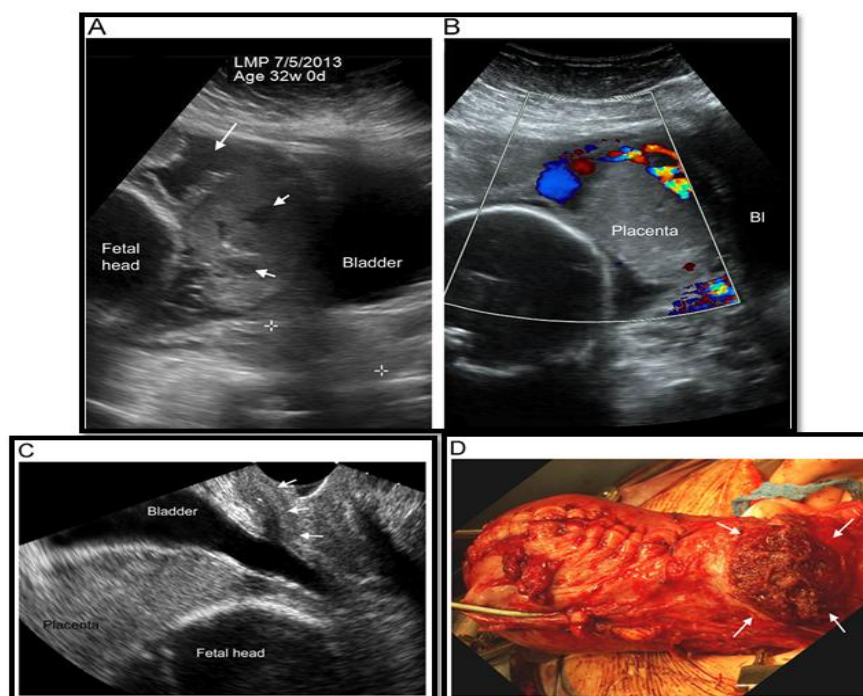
Morbidly adherent placenta. (A) TAUS in a patient with 5 prior cesarean deliveries shows abnormal placental echogenicity with multiple large lacunae (arrows). The region of the cervix is indicated by the asterisks. (B) color Doppler in the same case shows swirling blood flow in the largest lacuna seen on gray-scale imaging. (C) TVUS in a different case shows placenta extending to the bladder wall without intervening
